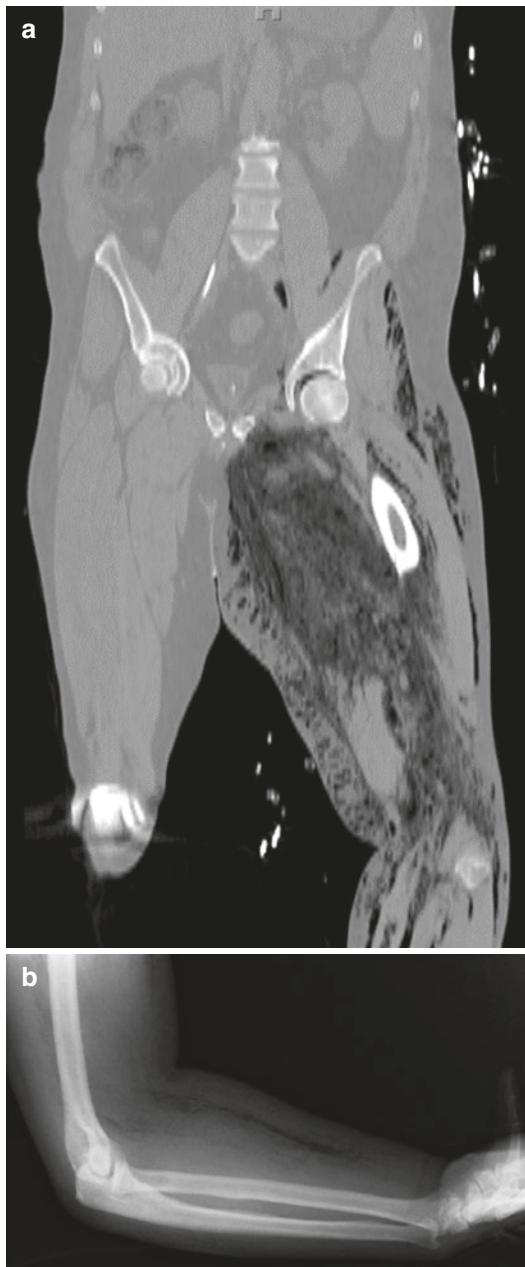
Fifty-one-year-old man who presented with acute mental status changes and was found to have acute leukemia and multifocal *Clostridium septicum* necrotizing fasciitis and myositis. Coronal reformatted CT image of the thighs (a) shows extensive deep fascial and intramuscular gas in the left thigh involving all three compartments. Right forearm radiograph (b) with soft-tissue gas tracking within the anterior forearm along muscles and fascia. Unfortunately, the patient succumbed to his disease
